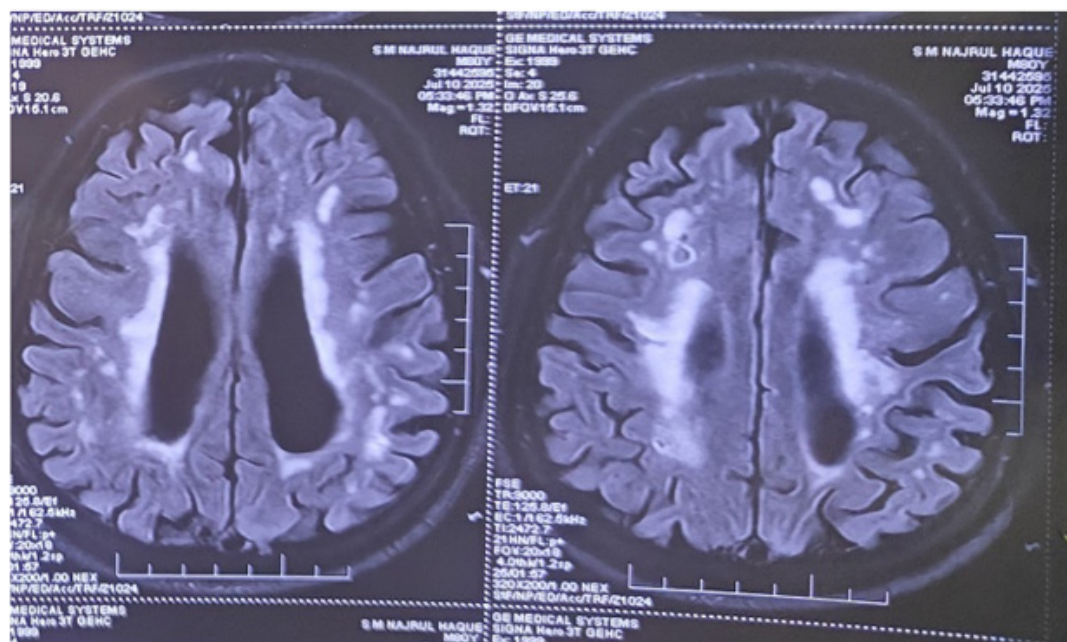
MRI of brain showing hyperintensities in the deep white matter, particularly in the periventricular regions, bilaterally and symmetrically and enlargement of the lateral ventricles which is consistent with subcortical atrophy.
